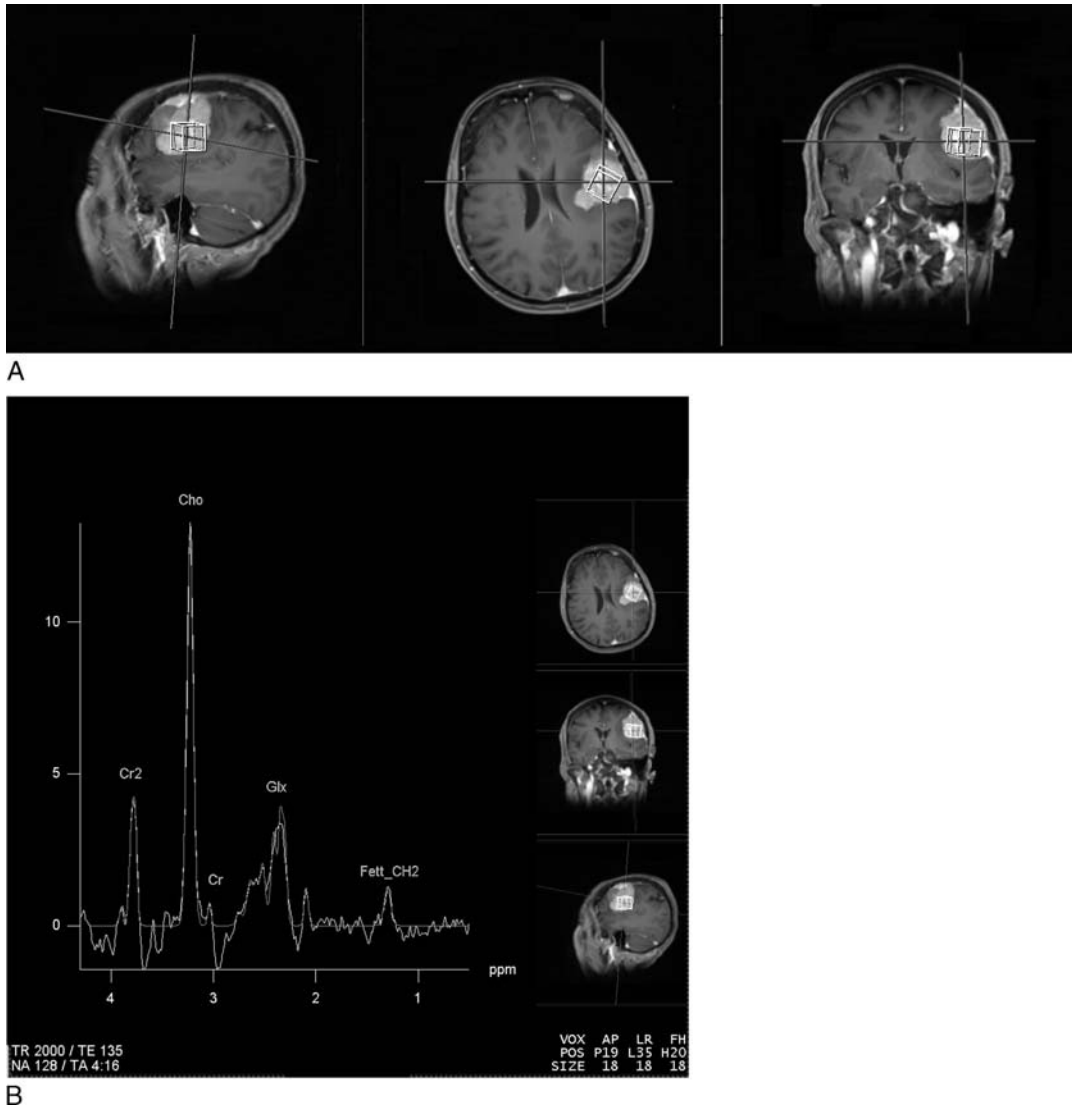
Magnetic resonance images (top row) and MRS (bottom row) of a meningioma. As this is an extra-axial lesion, the neuronal marker NAA is missing. There is almost no Cr and a small lipid peak (CH₂) but elevated Glx components (B).
